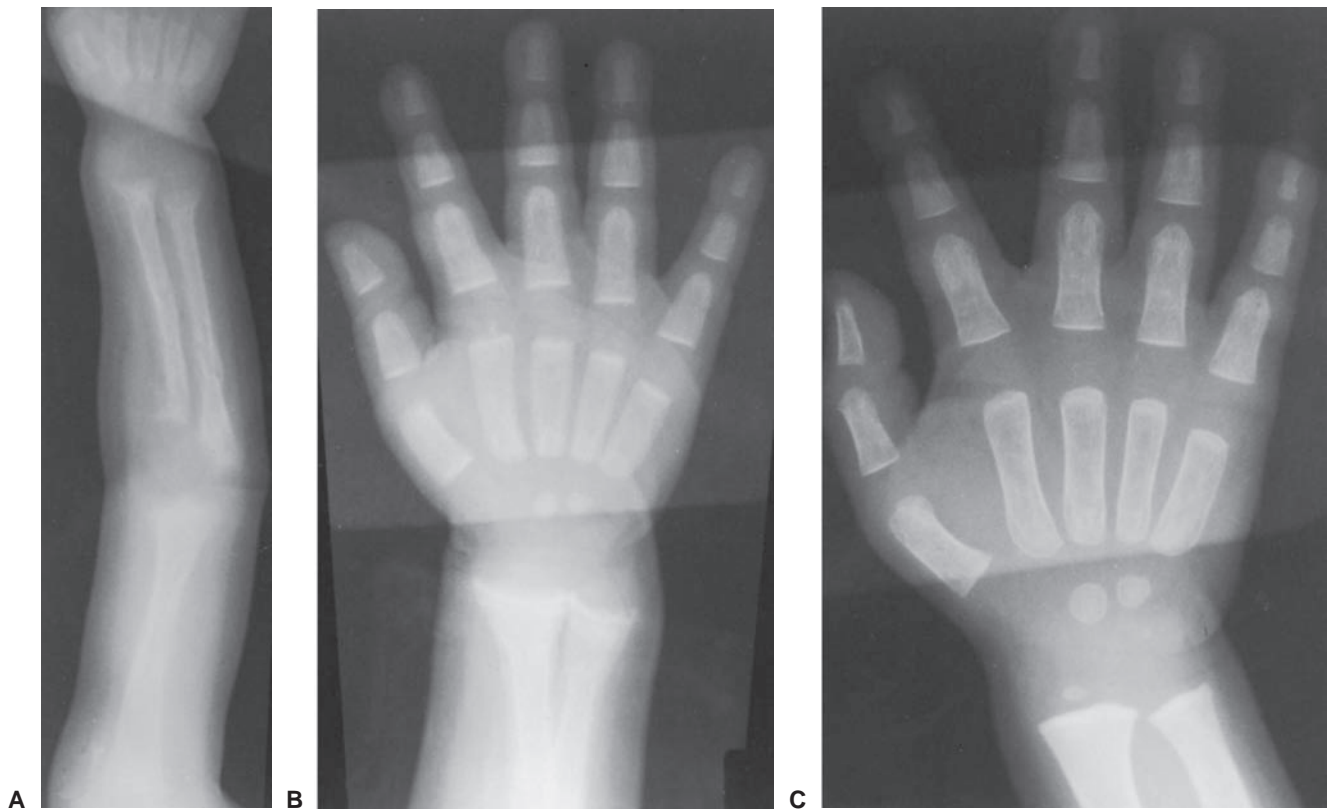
A: Rickets in an 11-month-old boy, breast-fed since birth. Roentgenogram of the upper extremity shows profound demineralization of the skeleton, with frayed, irregular cupping of the end of the metaphysis and poorly defined cortex. Note retardation of skeletal maturation. B: Same patient with some healing 4 weeks after supplemental vitamin D. Severe rachitic changes are noticeable. Periosteal cloaking, both of the metacarpals and of the radius and ulna, is evidence of healing. C: Complete healing of the rickets 8 months after treatment. Note the reappearance of the provisional zone of calcification. (Courtesy of Soroosh Mahboubi, MD, The Children's Hospital of Philadelphia.)
